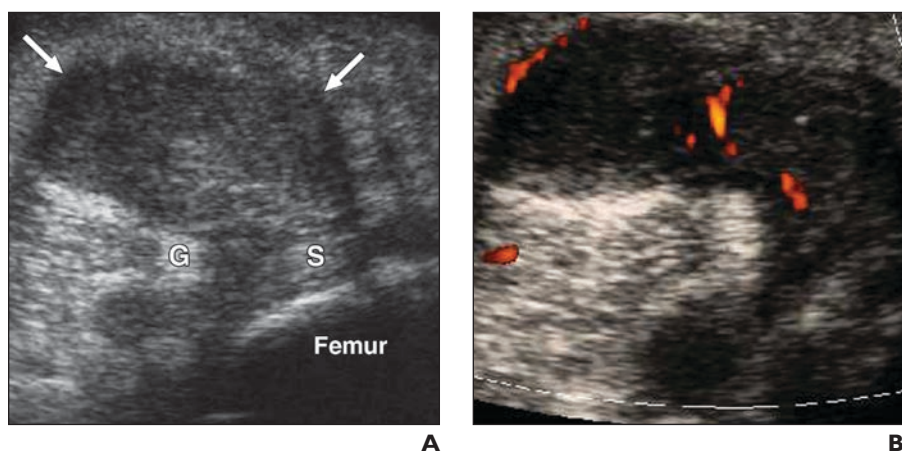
64-year-old woman with rheumatoid arthritis and posterior knee pain. MRI showed Baker cyst, and patient was referred for sonographically guided aspiration.
